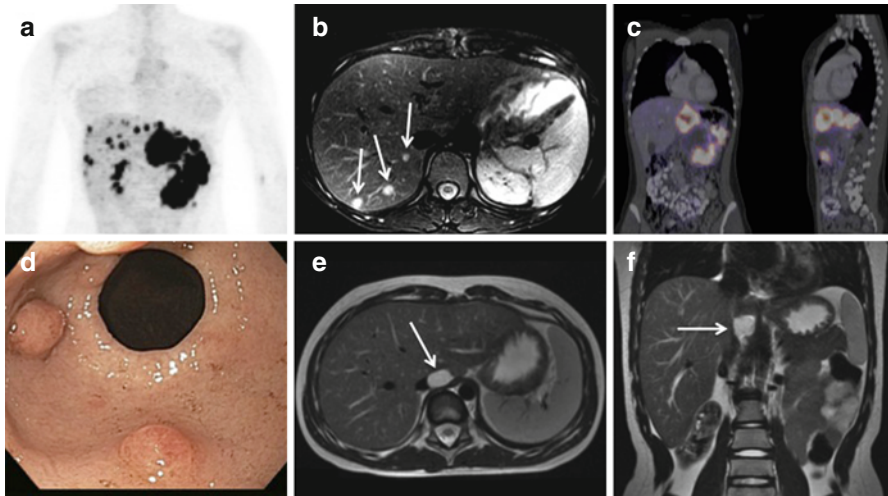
Typical imaging characteristics of SDH-deficient GIST. Patient with SDH-deficient GIST who presented with gastric GIST and liver metastases demonstrated on ^{18}F -FDG-PET (a), including a large gastric tumor (panel c, ^{18}F -FDG-PET), liver metastases which are best visualized with MRI (arrows, panel b), and multiple gastric tumors visualized with upper endoscopy (panel d). A different patient with SDH-deficient GIST with recurrence in a gastric lymph node (arrows, panels e and f, MRI)
